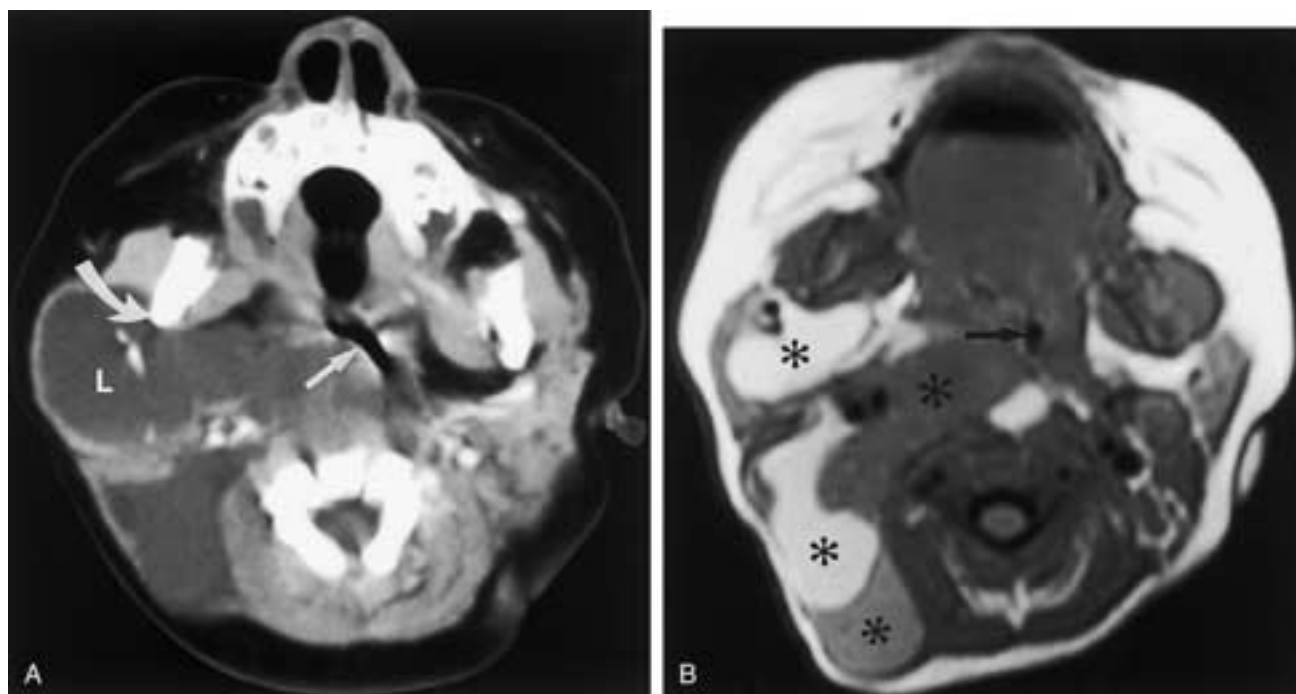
LM complicated by infection and subsequent hemorrhage in a 3-year-old boy. A, Axial contrast-enhanced CT reveals a low-attenuation macrocystic LM (*L*) encroaching on the airway (*straight arrow*). There is enhancement only of the margins and septations of the LM. Note the deformity and remodeling of the right mandibular ramus (*curved arrow*). This is a relatively common feature of LMs. B, Axial T1-weighted MR image reveals variegated high and intermediate signal intensity representing hemorrhage within the macrocystic LM (*asterisks*). The LM distorts and compresses the oropharynx (*arrow*).
